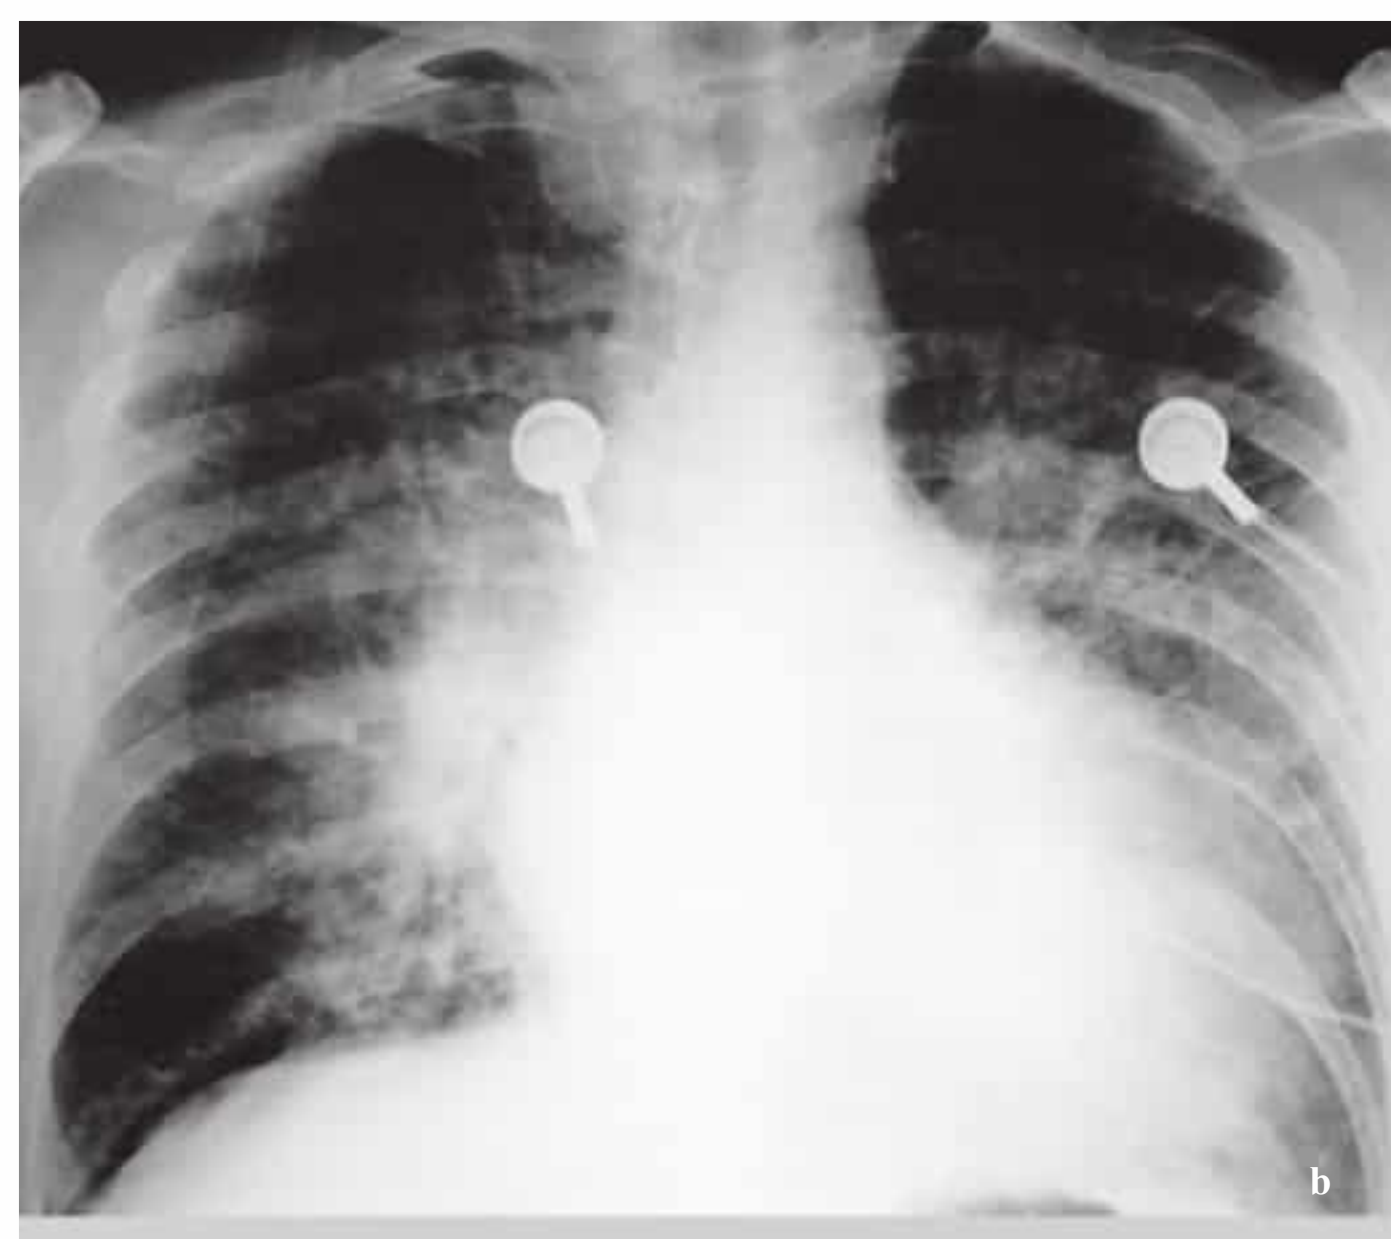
Supine chest radiograph. Recent anterior wall infarction following coronary artery bypass graft. Acute left-sided heart failure. Although cardiac size is normal for a supine radiograph, interstitial lung edema is nevertheless present. Apart from some fine, moist rales, no abnormal finding on auscultation.
